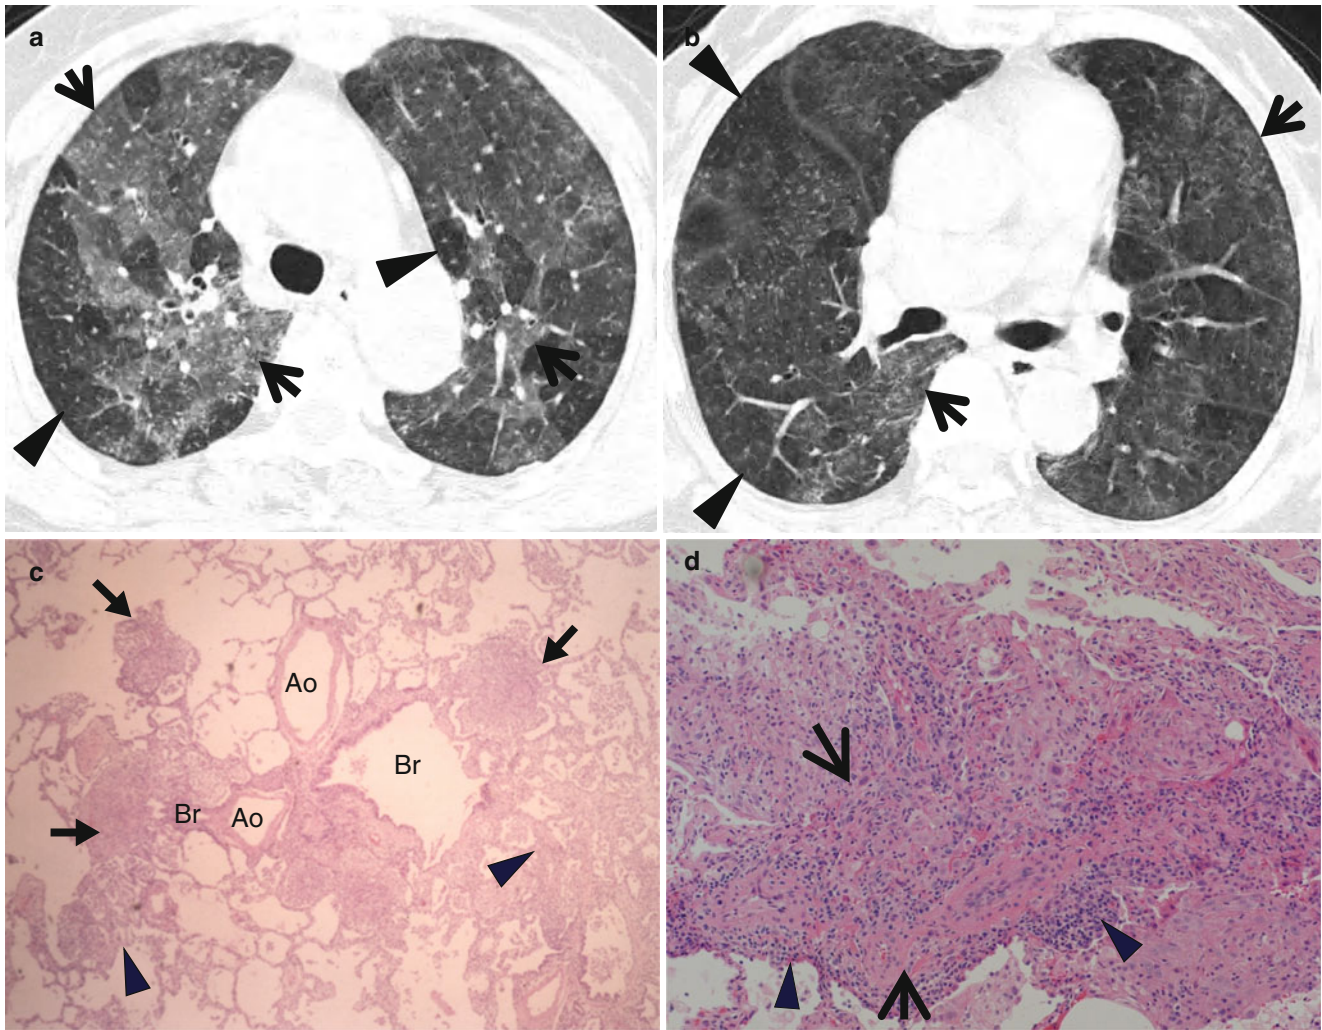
Subacute hypersensitivity pneumonitis in a 66-year-old woman. (a, b) Lung window images of thin-section (1.0-mm section thickness) CT scans obtained at levels of azygos arch (a) and distal bronchus intermedius (b), respectively, show the so-called head cheese sign with mixed infiltrative (ground-glass opacity, *arrows*) and obstructive (mosaic attenuation, *arrowheads*) abnormalities. Ground-glass opacity is caused by lung infiltration, whereas mosaic perfusion with decreased vessel sign is usually caused by small airway disease. (c)
